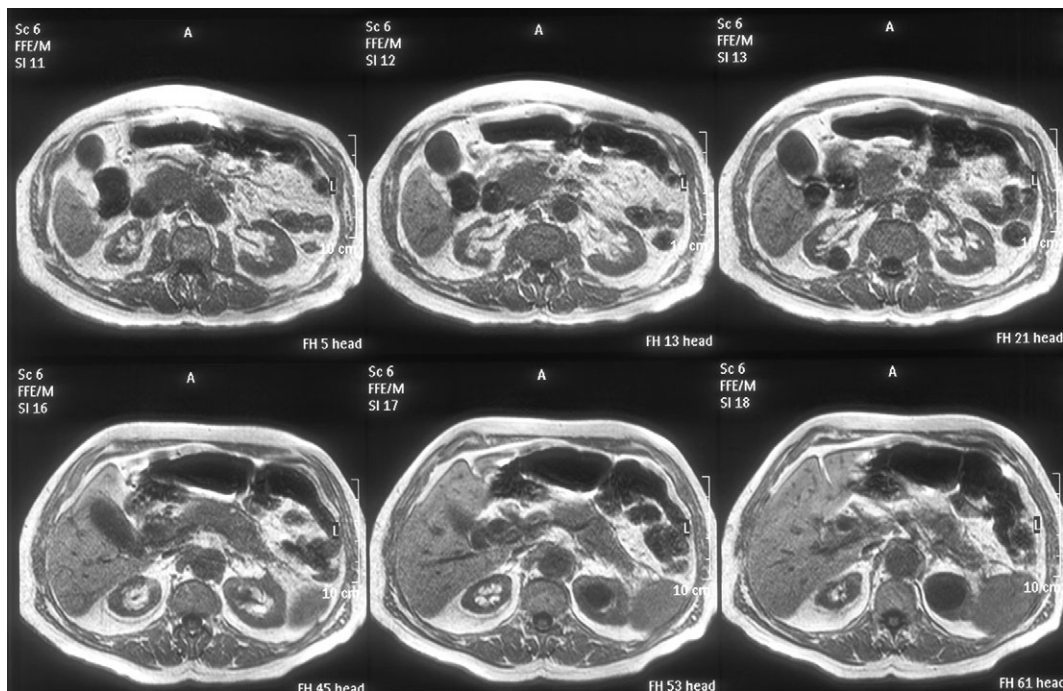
MRI showing diffuse pancreatic enlargement
